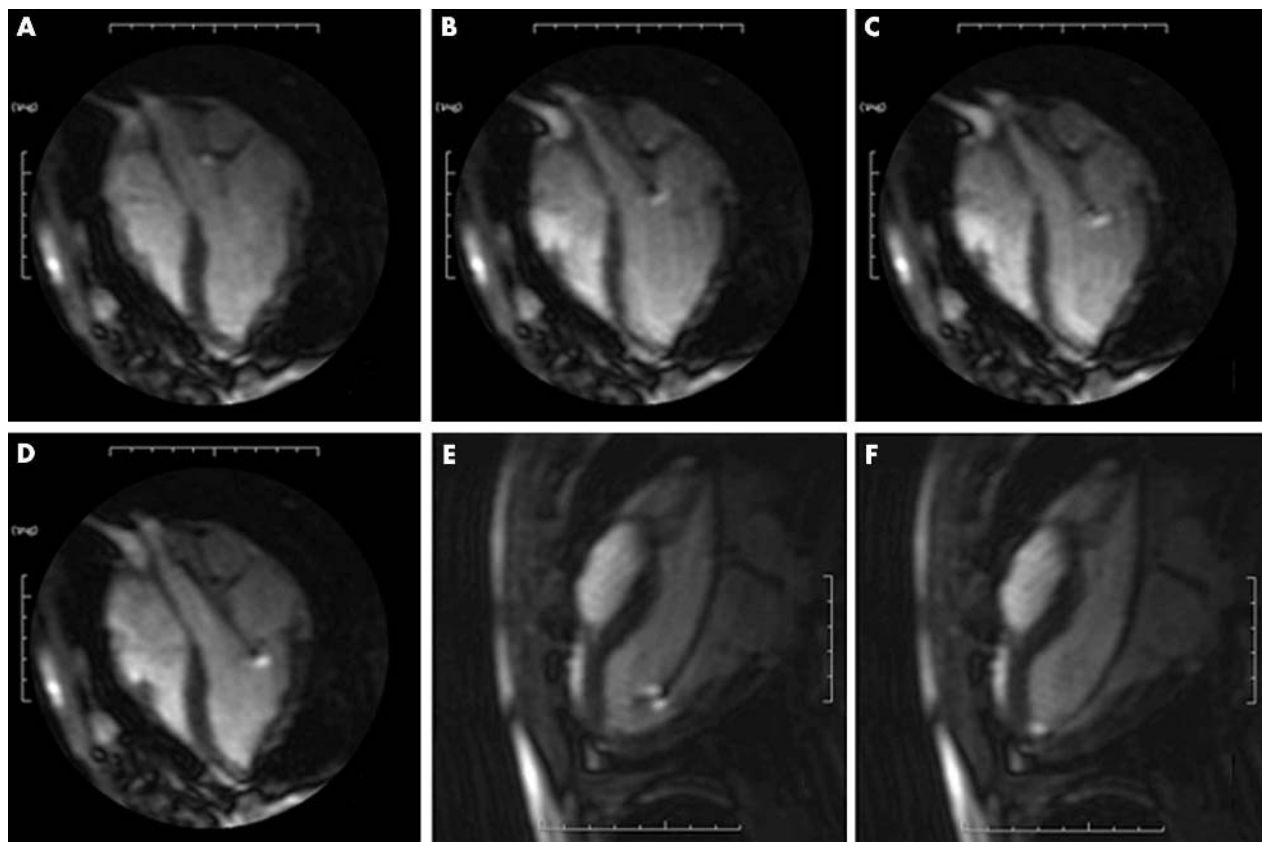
Serial MR images acquired in real time showing the entry of the catheter into and movement within the left ventricle. (A–D) The image plane across the valve was a modified two chamber view, displaying the left ventricular outflow tract and apex. (E, F) Images taken in long axis view, during which the catheter tip was deflected and rotated towards the apex.
